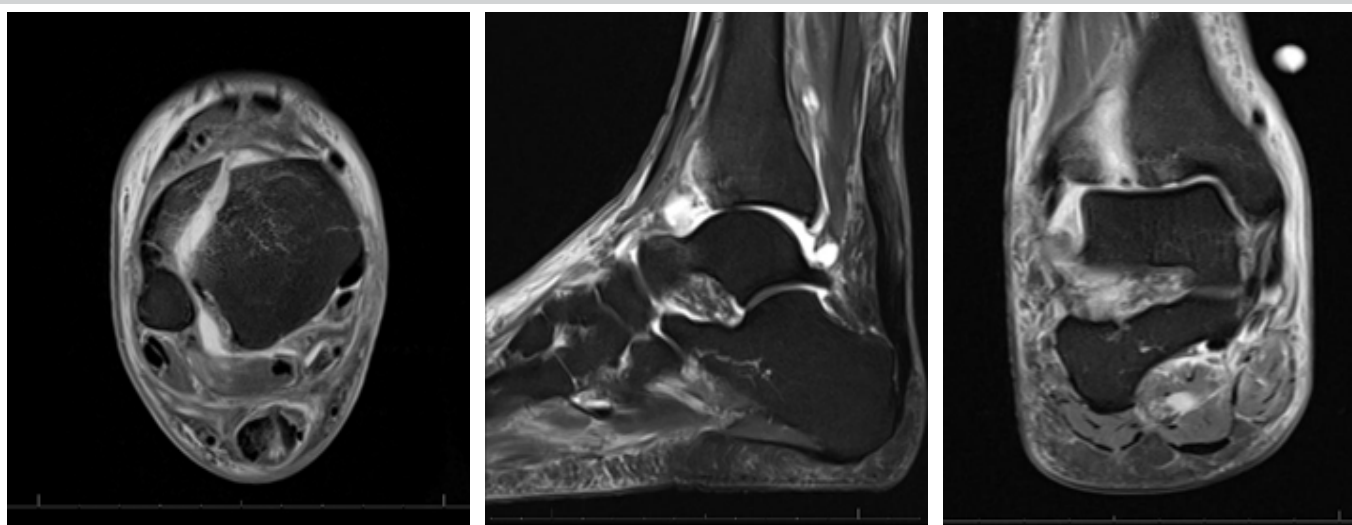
Pre-operative magnetic resonance imaging (MRI): Pre-operative MRI demonstrating recent non-insertional Achilles tendon rupture as well as syndesmotic and deltoid ligament ruptures with associated malalignment.
